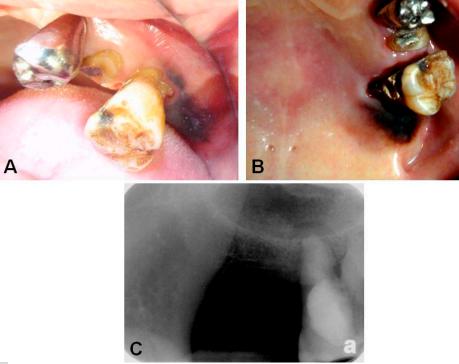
Buccal (A) and palatal (B) aspects of the blackish blue lesion; (C) The intraoral periapical radiograph of the region of edentulous alveolus of third molar revealed surface erosion of the underlying bone
